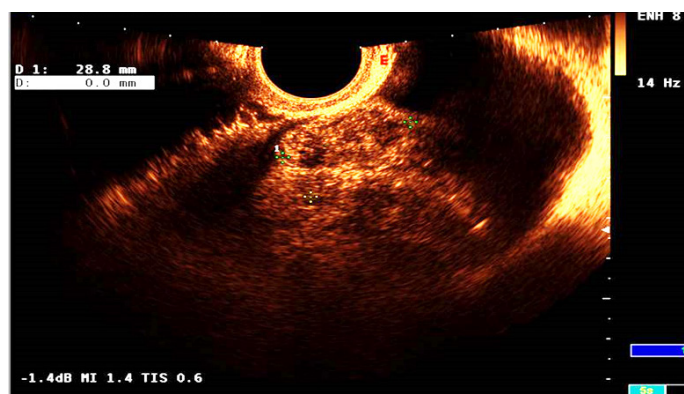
DIE appearance in the bladder on 2D ultrasound.
